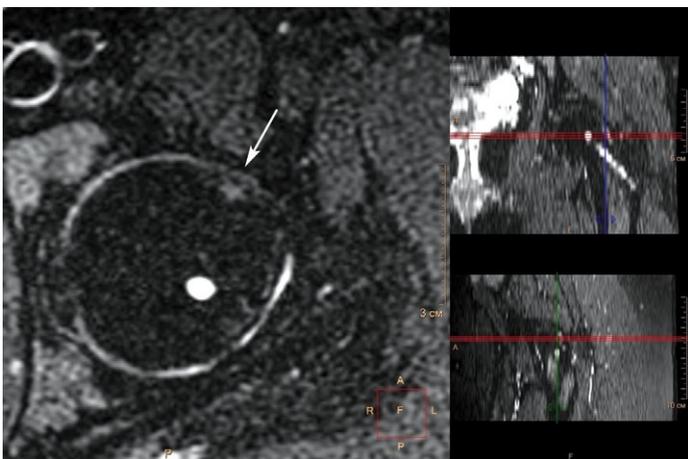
MRI of the left hip (axial projection, fat suppression image) of patient 18 years 4 months old, 4 years 5 months after surgery: fibrocyst (indicated by an arrow) localized at the anterior superior margin of the femoral neck at the edge of the articular surface (at the area of impact)
